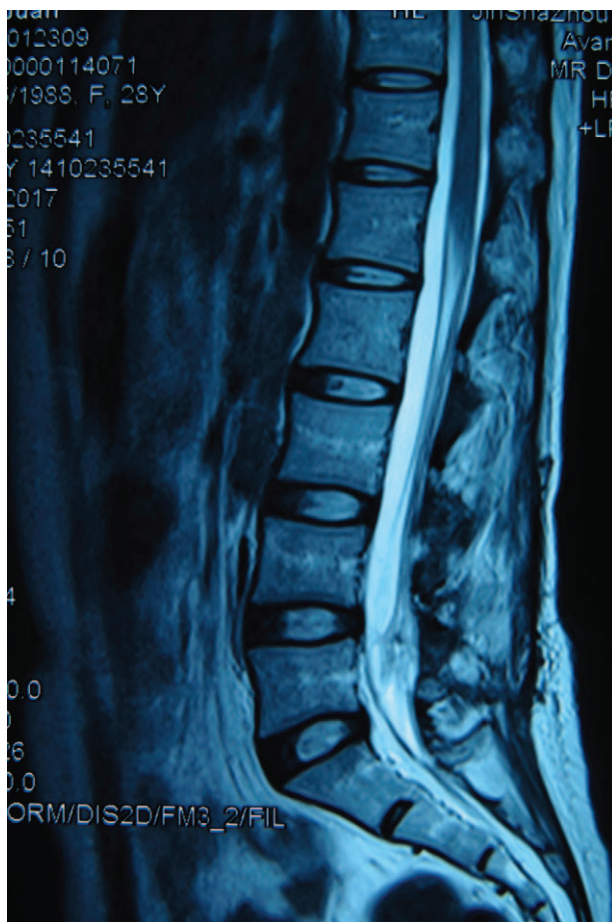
Three-month postoperative magnetic resonance images (MRI). Three-month postoperative MRI confirmed that the spinal epidermoid cyst had been completely removed.
